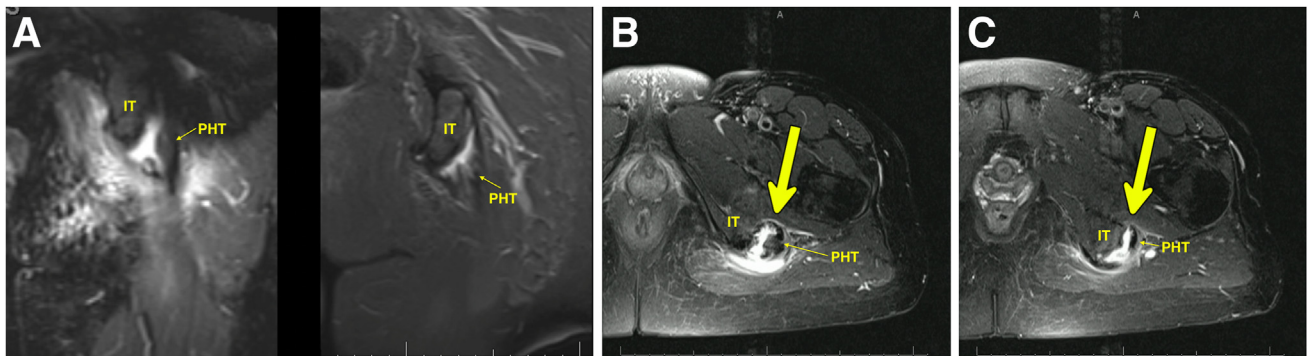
Magnetic resonance imaging (MRI) images of left hip. (A) Two coronal views and (B-C) two axial views showing the proximal hamstring tendon (PHT) is separated from ischial tuberosity (IT) (large yellow arrows), but with minimal displacement, consistent with chronic tendinopathy with partial avulsion.
